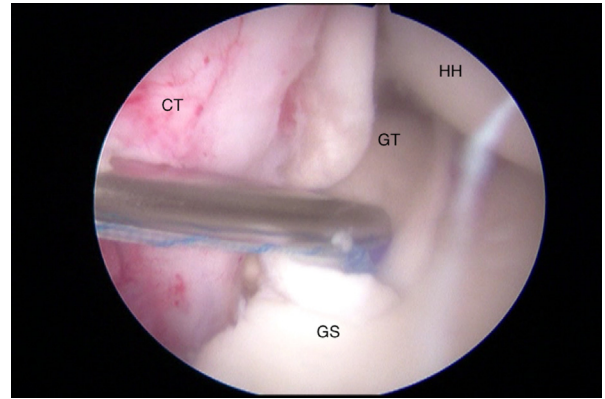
The medial aspect of the graft is pulled down to the glenoid by pulling the glenoid anchor sutures that are coming through the posterior portal. Once the allograft is seated on the glenoid, the grasper is used to pull the STIK knot of the glenoid anchor suture, and then it is tied down with an SMC knot. A view from the anterosuperior portal on the right shoulder. CT, capsular tissue; GT, graft tissue; GS, glenoid surface; HH, humeral head.
